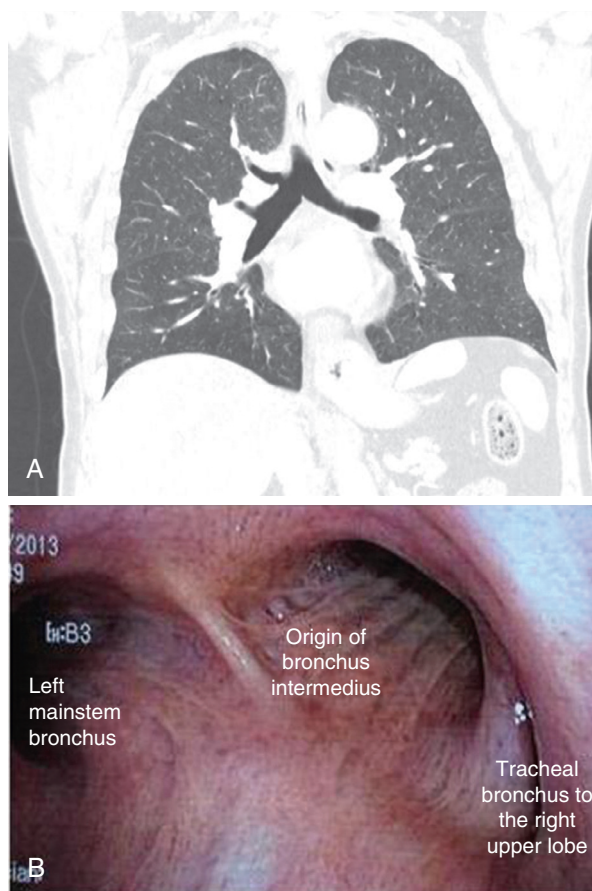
■ A, Coronal view of a computed tomography scan showing a tracheal bronchus. B, Bronchoscopic view of the origin of the right upper lobe bronchus from the trachea.
